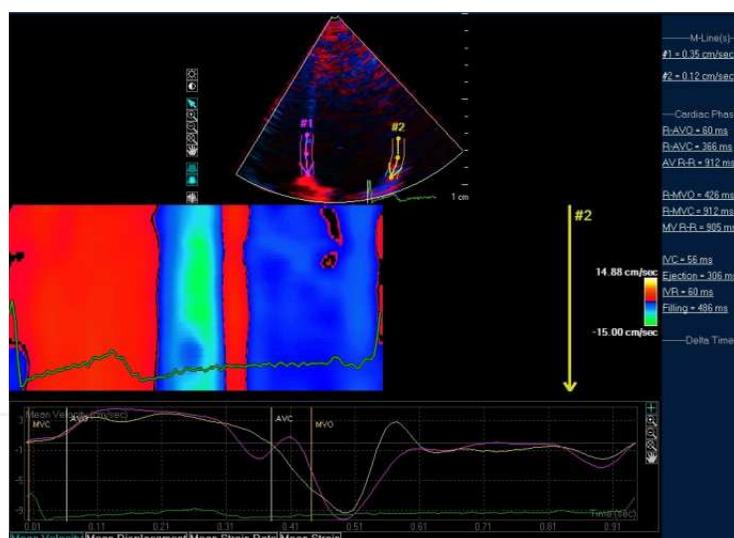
Tissue Doppler Imaging for assessment of regional myocardial velocities. Apical 4-chamber view with regional analysis of the septal and lateral walls. Region of interest include the basal segments and systolic and diastolic velocities in the averaged cardiac cycle are presented as color M-mode imaging and curves over time.
